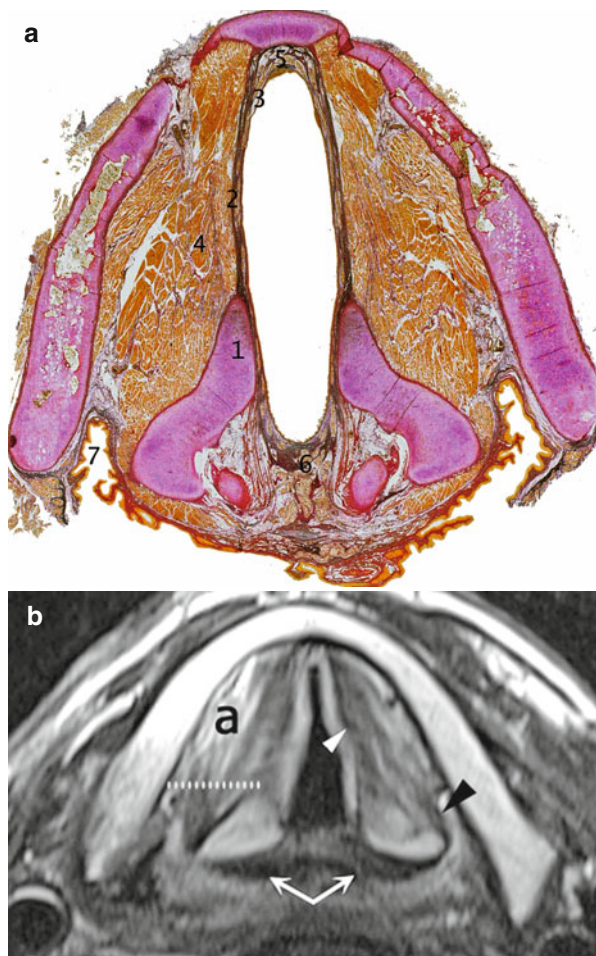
(a) Axial macrosection of the larynx on glottic plane. 1 Vocal process of arytenoid cartilage, 2 vocal ligament, 3 epithelial layer, 4 vocal muscle, 5 anterior commissure, 6 posterior commissure, 7 piriform sinus. (b) Larynx MRI: T2-weighted sequence on axial plane. Vocal muscle (white arrowhead) and vocal cord mucosa (hyperintense layer on the luminal surface of the muscle); insertion of the lateral cricoarytenoid muscle on the muscular process of arytenoid cartilage (dark arrowhead); paraglottic space (a); interarytenoid muscle (arrows)
